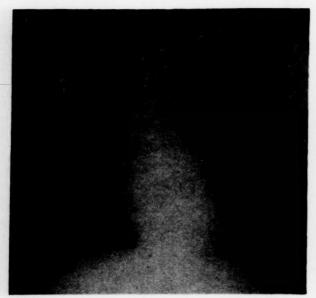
X-ray of the chest four months after onset of symptoms and two months prior to cortisone therapy.
